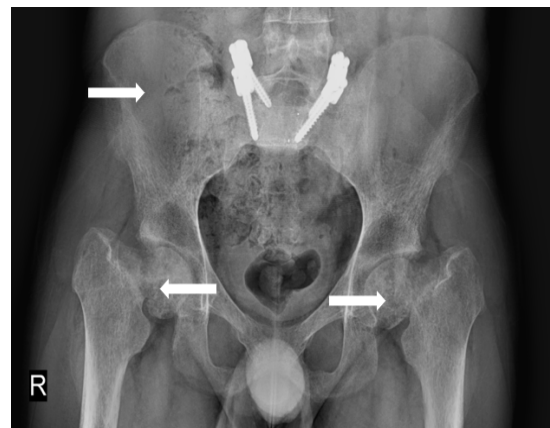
XRAY of the pelvis and hips demonstrating bilateral coxa vara with subcapital fracture of the right femur. Bilateral pedicle screw hook fixation can be observed due to the treatment of bilateral spondylolysis.
